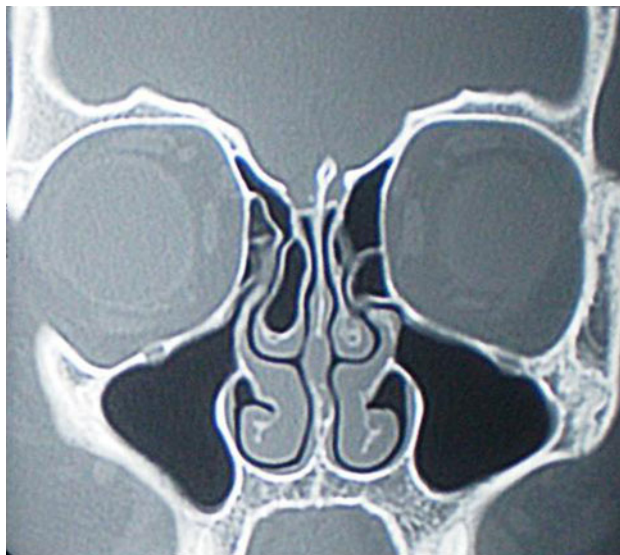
Maxillary sinuplasty: CT scan 1 month postoperatively
